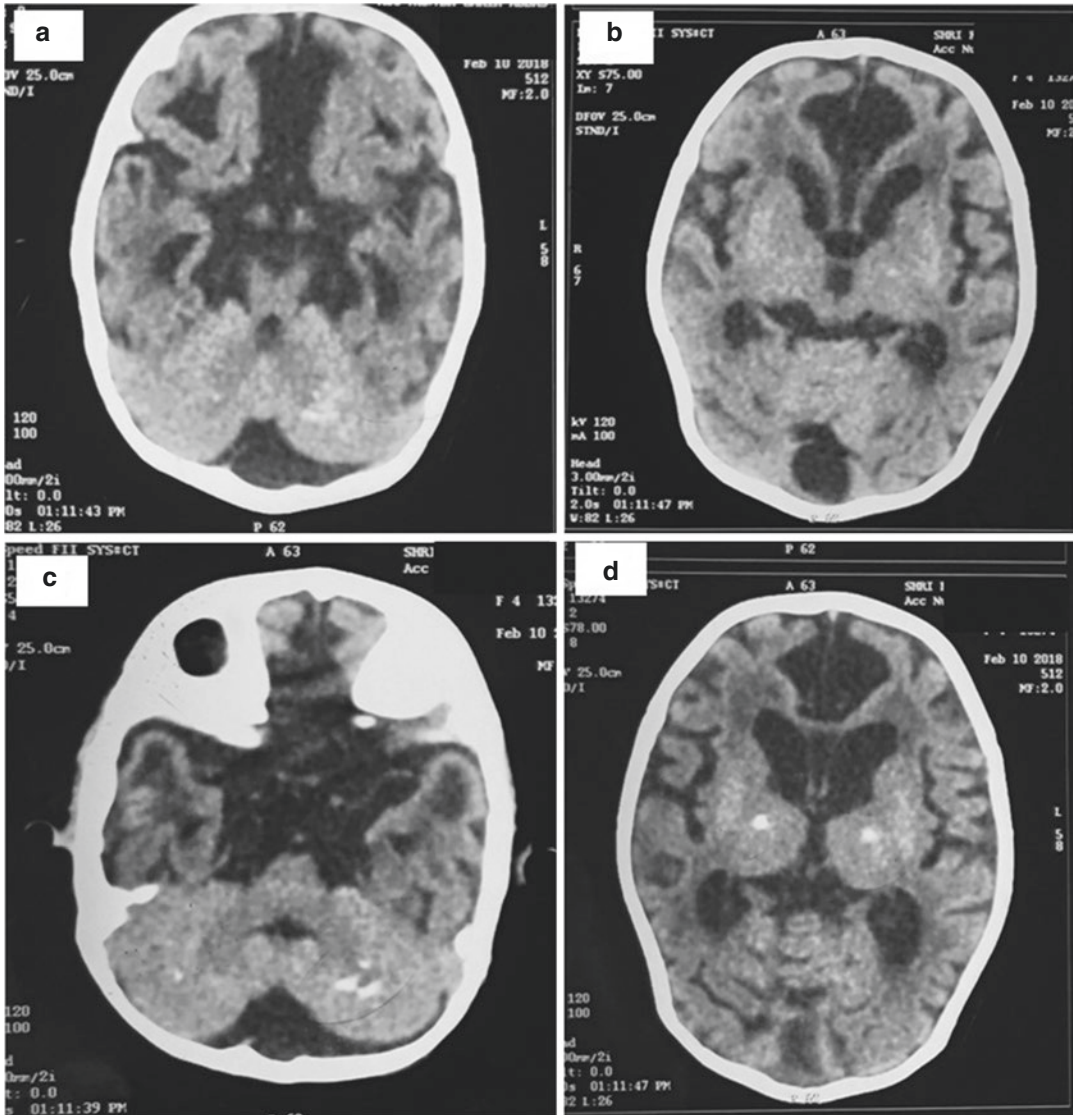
CT brain images of a patient with *TREX1* mutation related to Aicardi Goutières syndrome: (a) Marked cerebral atrophy, white matter abnormalities in temporal lobe; (b) Marked cerebral atrophy, white matter abnormalities in the frontal lobe, basal ganglia calcification; (c) Temporal lobe cysts, cerebellar calcification; (d)
